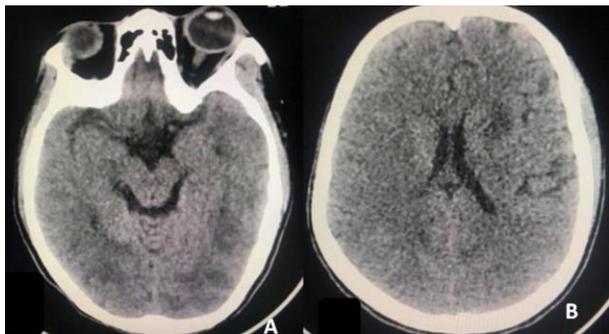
(A, B) Plain CT scans of head showing intra-axial hypo-densities over bilateral parieto-occipital lobes and Left caudate head.
